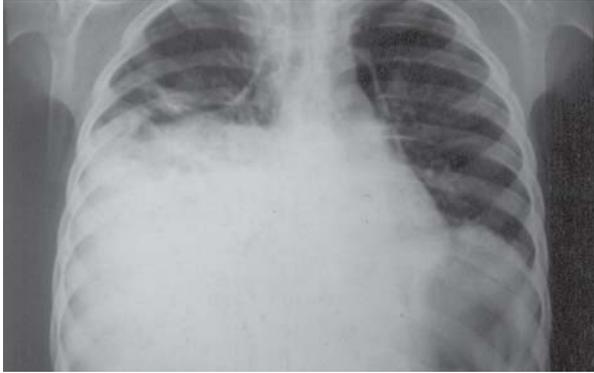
X-Ray chest showing opacities in right mid and lower zone
